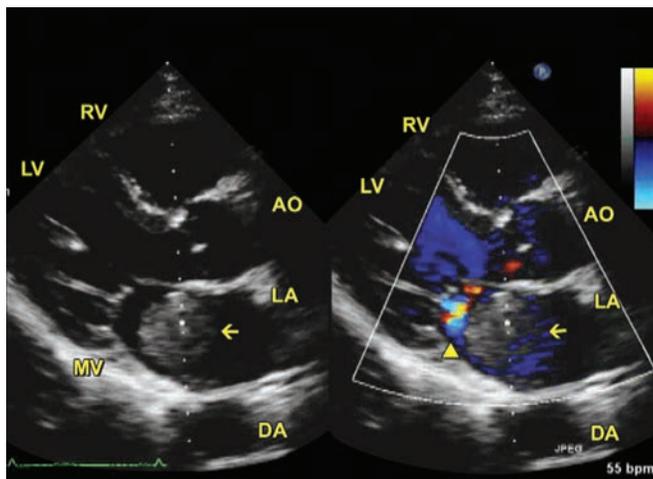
TTE. Parasternal long axis view. A large mass (arrow) is seen in the LA.
